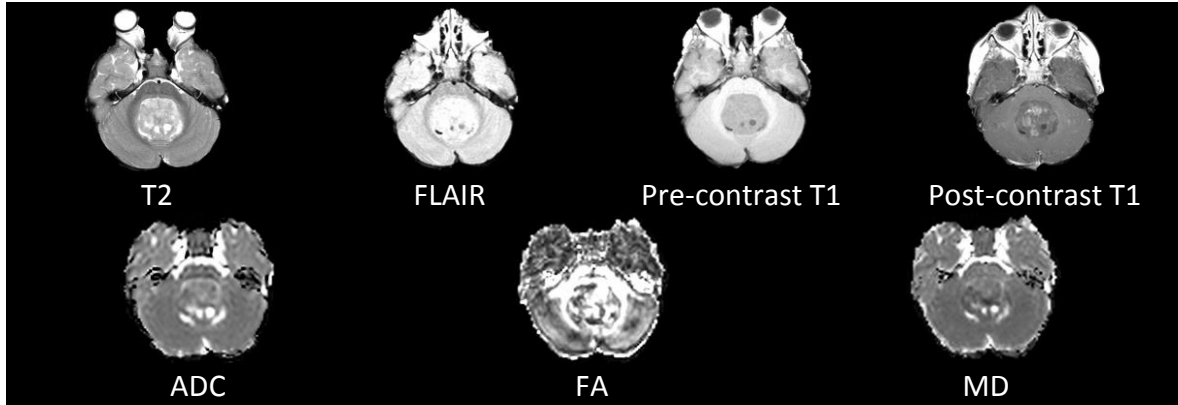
Successful registration for a medulloblastoma with NMI cost function shows the same slice of T2, FLAIR, pre-contrast T1, post-contrast T1, ADC, FA and MD (case MB719).
